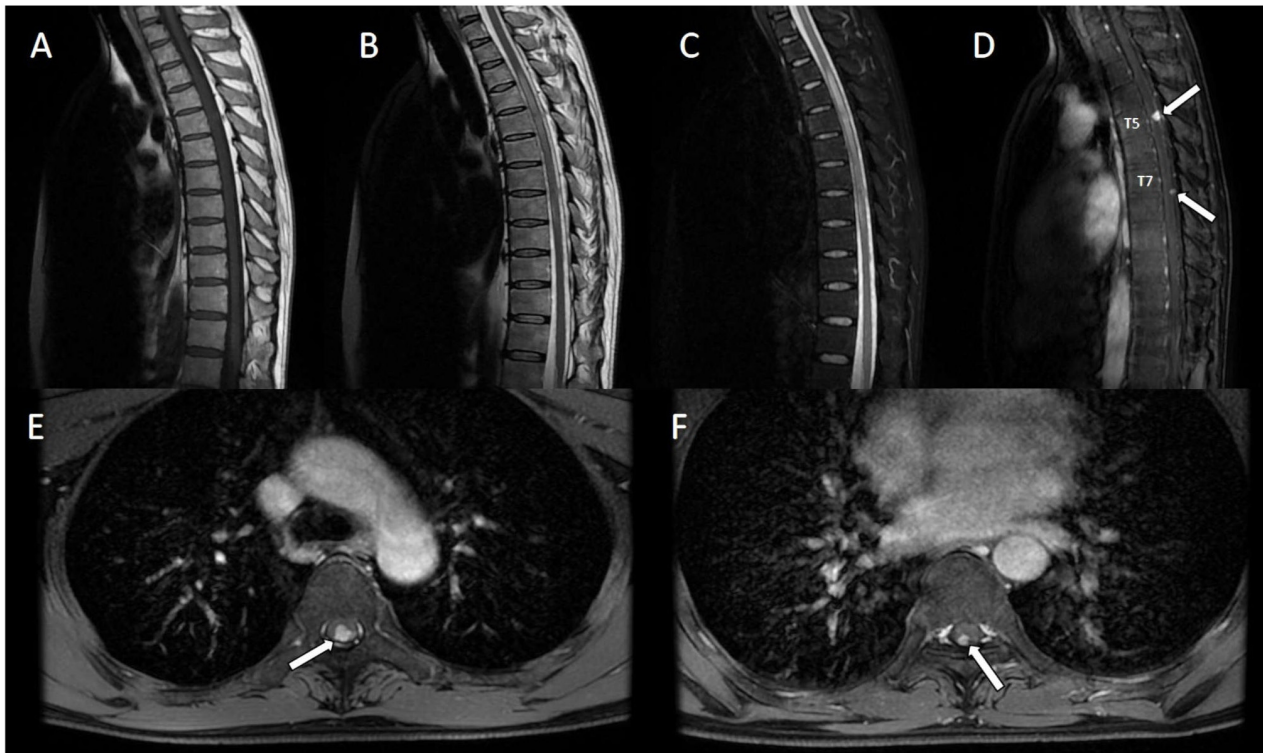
Spinal MRI scans of the intramedullary lesions. (A) Sagittal T1-weighted image revealing a strip-like slightly hypointense signal extending from the T3 to T9 vertebral levels. The corresponding slightly hyperintense signal is observed in (B) T2-weighted and (C) short TI inversion recovery images. (D) Sagittal T1-weighted contrast-enhanced image demonstrating contrast enhancement of the intramedullary nodules, as indicated by arrows within the figure. Axial T1-weighted contrast-enhanced images at the (E) T5 and (F) T7 vertebral levels confirmed the presence of well-defined, contrast-enhancing intramedullary nodules, which are indicated by arrows within the figure.
